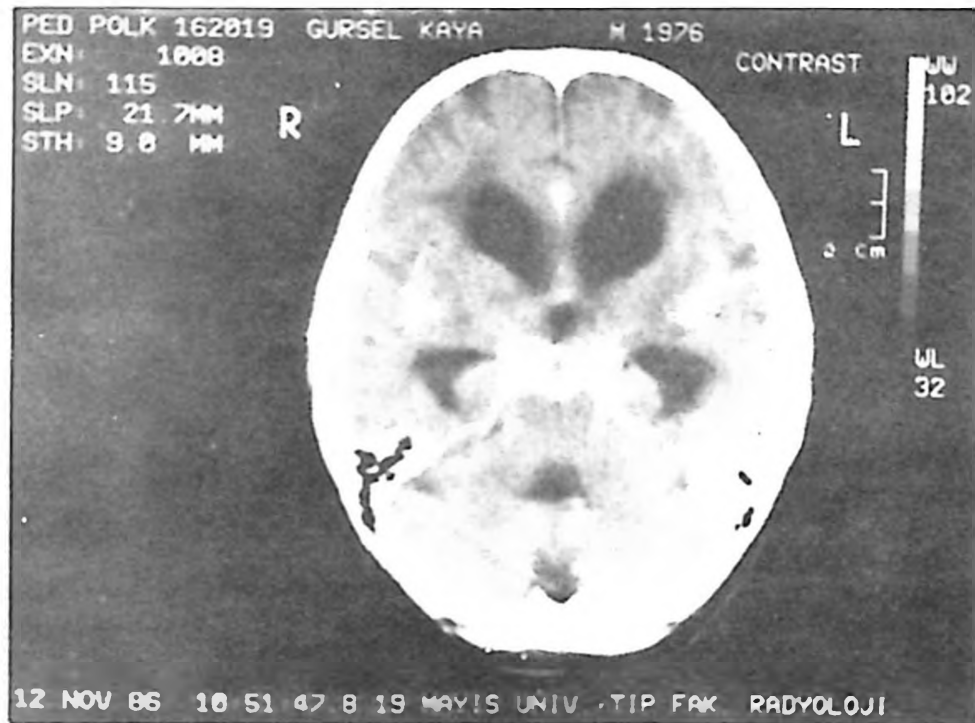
Follow-up postcontrast CT study of Case No. 3 shows a decrease in hydrocephalus. Basal exudates have also been reduced.
